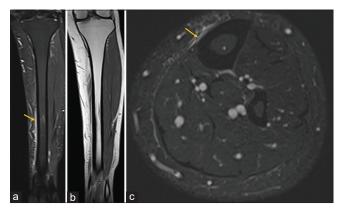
A 31-year-old with shin pain with Grade 1 MTSS. (a and c) Coronal and axial STIR images show hyperintense periosteal edema along the medial side of tibia. (b) Corresponding coronal T1-weighted image shows no significant abnormality.
